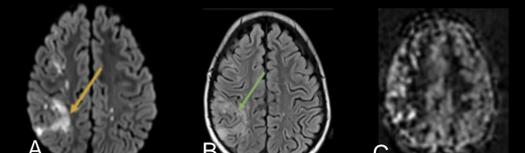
7-year-old boy with sickle cell disease presenting chest pain and headache found to have multiple foci of developing infarct on DWI (A) and FLAIR (B). PASL revealed hypoperfusion in areas of infarct, but also patchy foci of intravascular enhancement in the right MCA territory likely secondary to narrowing of proximal vessel.
